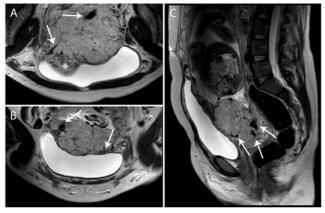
A, B: Axial and C: Sagittal T2-weighted magnetic resonance images obtained at 30 weeks of gestation, showing a placenta with heterogeneous signal, lumpy contour, rounded edges, dark intraplacental bands (arrows A, B and C), hypointense line disruption at the myometrial interface, and placental tissue bulging into the bladder (asterisk, A).
